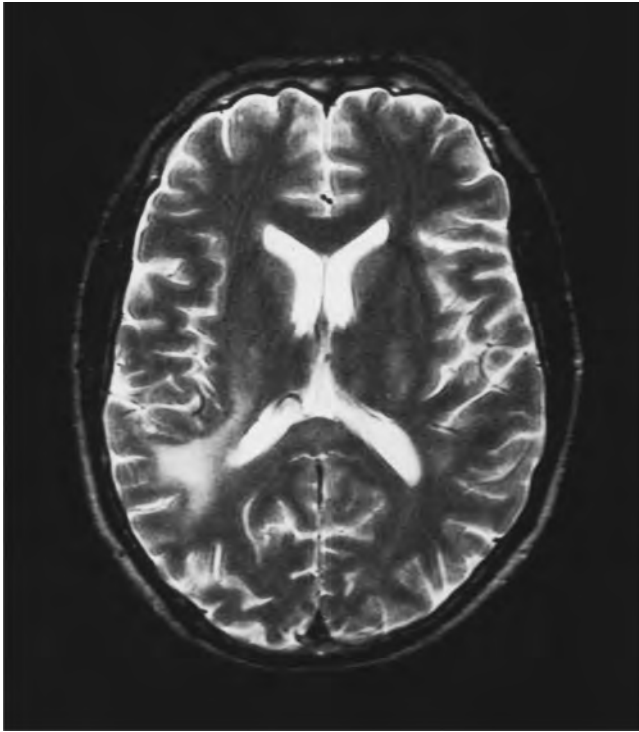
Adrenoleucodystrophy (MRI T2W axial).
